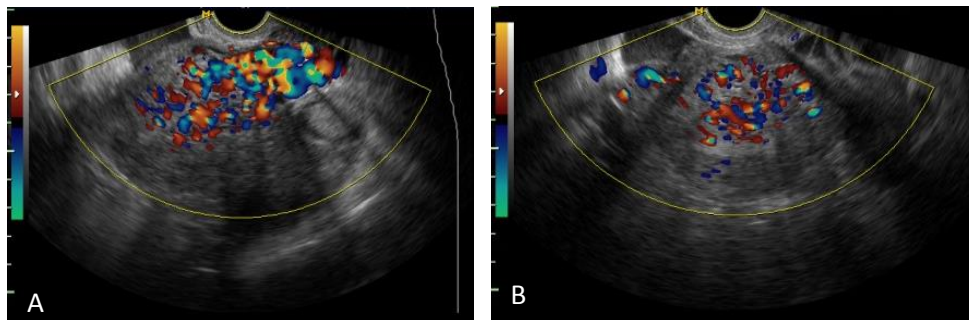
A (Sagittal view) and 2 B (Transverse view). Color Doppler ultrasound in this case shows a mosaic flow within the tubular structure with color aliasing.
